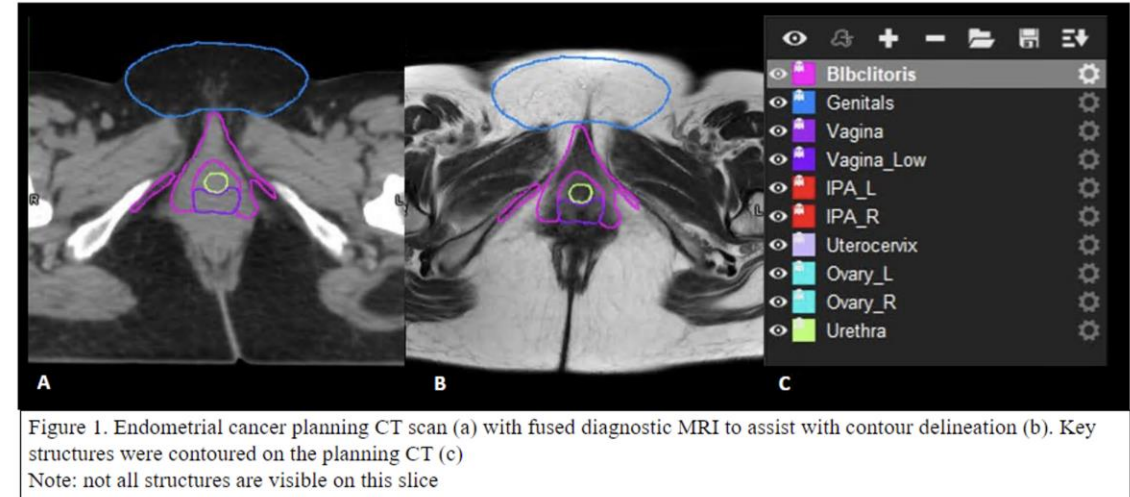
Endometrial cancer planning CT scan (a) with fused diagnostic MRI to assist with contour delineation (b). Key structures were contoured on the planning CT (c)
